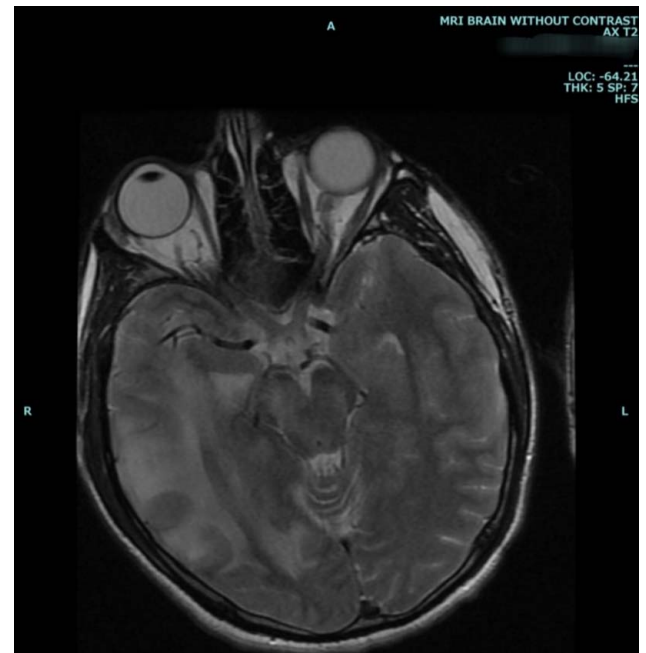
MRI brain without contrast. Shows an expansile T2 hyperintense signal in the midbrain, pons, middle cerebellar peduncles, right pontomedullary junction, right anterior cerebellar hemisphere, extending into the splenium of corpus callosum, right side of the thalamus, and the posterior basal ganglia; edema in the supratentorial brain involving the right frontal parietal temporal lobes, posterior basal ganglia, and right thalamus with a shine-through effect on diffusion-weighted sequences without definite restricted diffusion.
